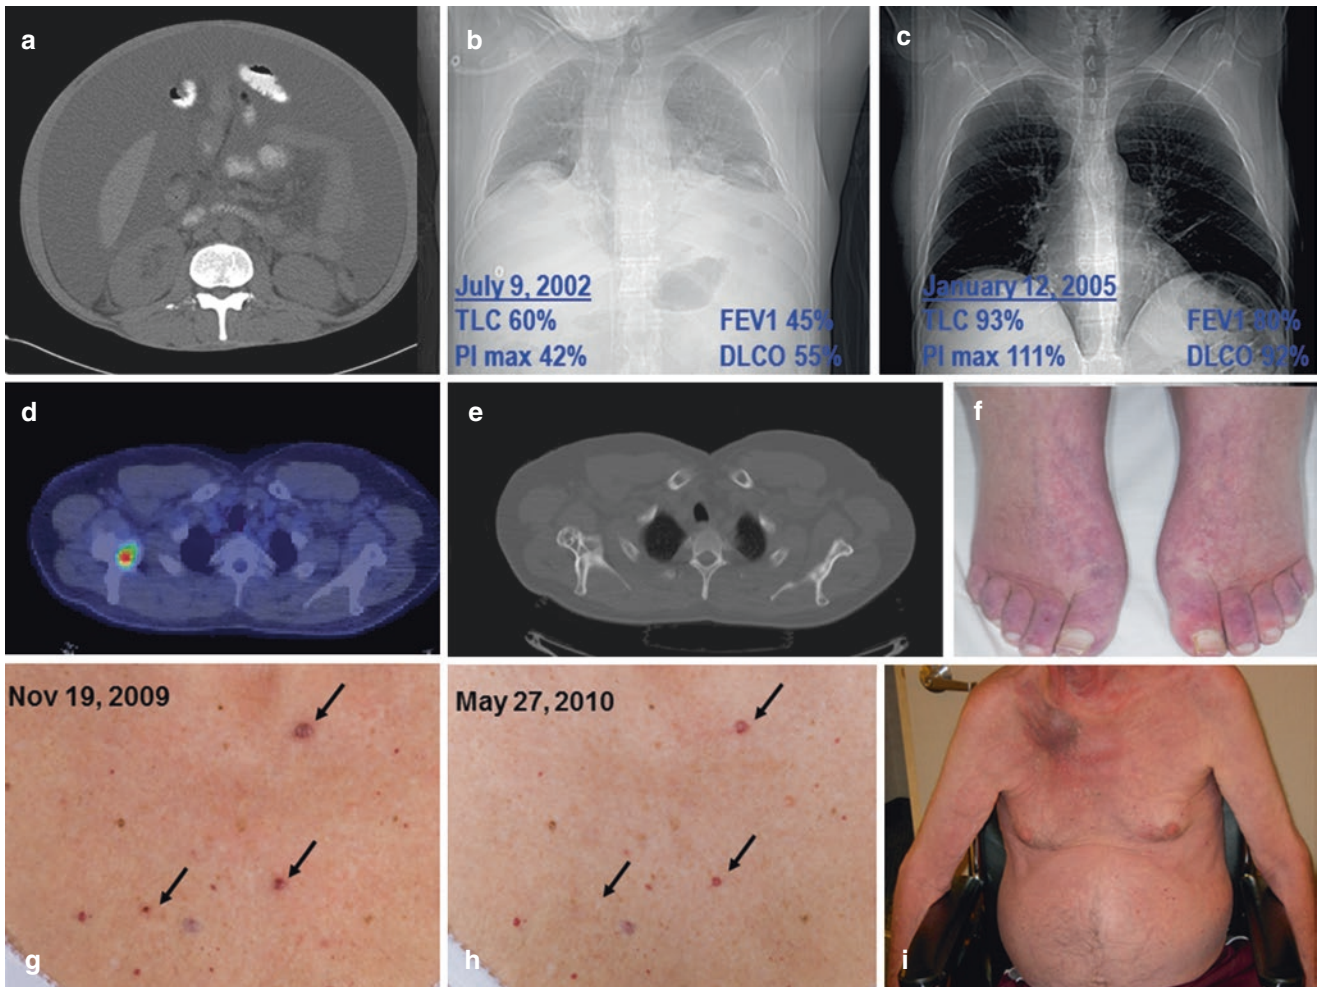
Classic findings of POEMS syndromes. *Reproduced with permission from Dispenzieri, A., How I treat POEMS syndrome. Blood, 2012. 119(24): p. 5650–8.* (a) Massive ascites and lipodystrophy. (b) Chest radiograph and pulmonary function test results demonstrating reduced lung volumes due to neuromuscular weakness, small effusions, and reduced diffusing capacity of carbon monoxide. (c) Improved chest radiograph and pulmonary function tests 2.5 years after ASCT (same patient as h). (d) Fusion CT PET of mixed lytic/sclerotic lesion in right
